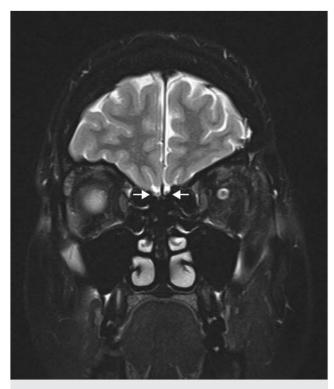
High-resolution T2-weighted magnetic resonance image in the coronal plane demonstrates the olfactory bulb/tracts (*arrows*) in the anterior cranial fossa inferior to the frontal lobe.
